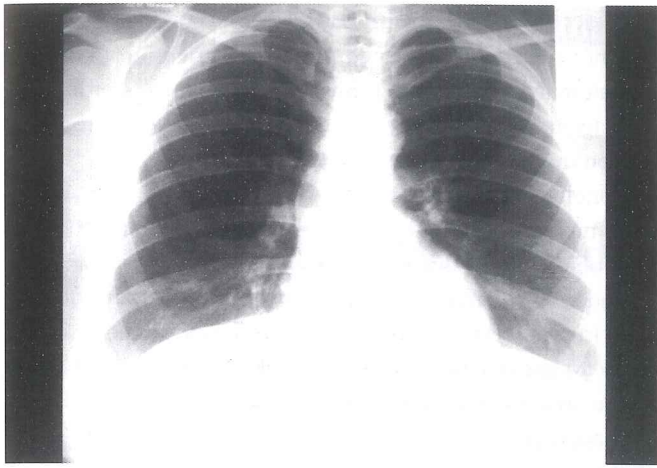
Chest radiograph of the second patient showing bilateral hilar enlargement, reticular infiltrates and cystic changes in the middle and lower zones of both lungs.
